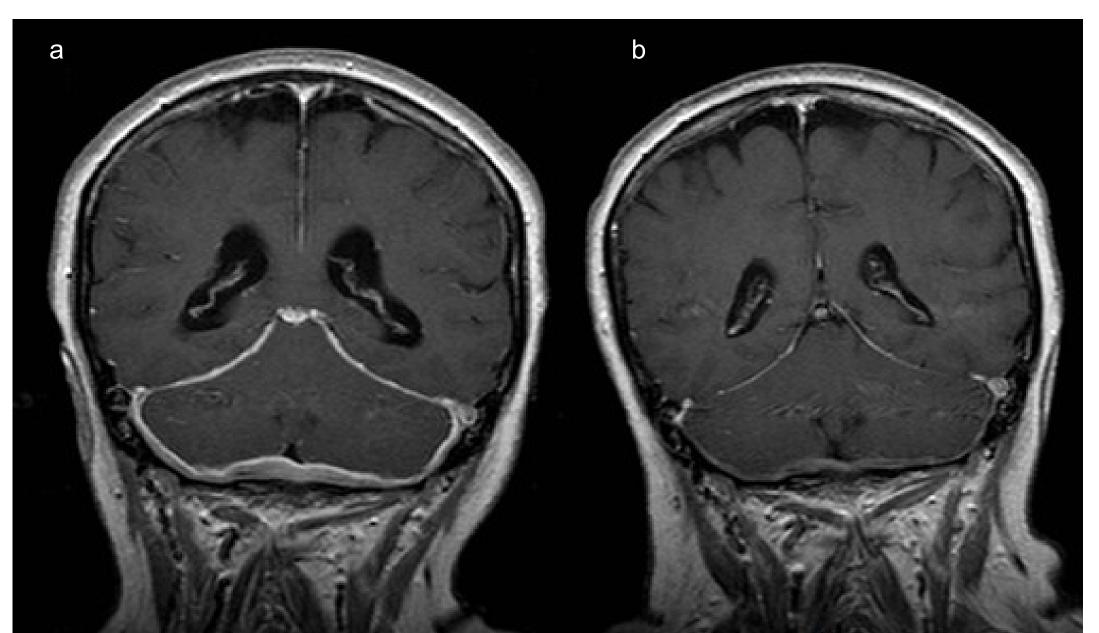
Coronal T1 weighted MRI with gadolinium showing pericerebellar dural enhancement and thickening (a). After methylprednisolone treatment and plasma exchange therapy the same sequence showed marked reduction of meningeal post-contrast enhancement (b).
